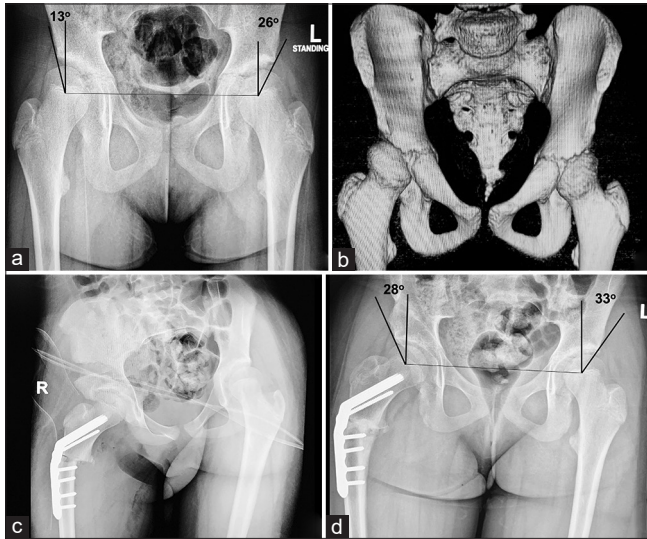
An 11-year-old girl who was treated for bilateral DDH by closed reduction at 6 m of age, presenting with right hip pain, limping on exertion, positive Trendelenburg test, and increased internal rotation (85°) with loss of external rotation. (a) AP standing radiograph of the pelvis shows residual right acetabular dysplasia with coxa valga of the right hip and reduced central-edge angle. (b) 3D-CT scan shows acetabular dysplasia and femoral anteversion. (c) Immediate post-operative radiograph after Pemberton acetabuloplasty and femoral varus derotation osteotomy with no cast. (d) Radiograph 6 months after surgery with good acetabular cover and normal center-edge angle.
